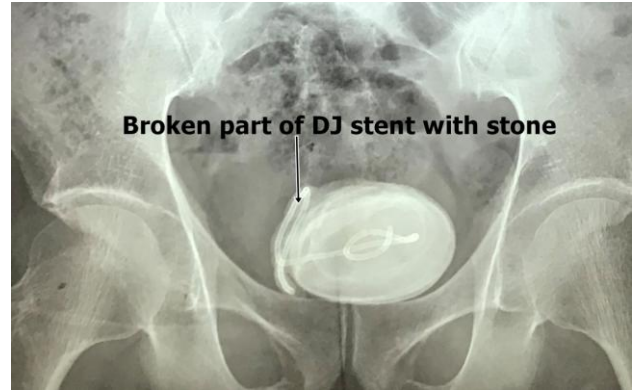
X-ray of broken DJ stent with stone over it.
